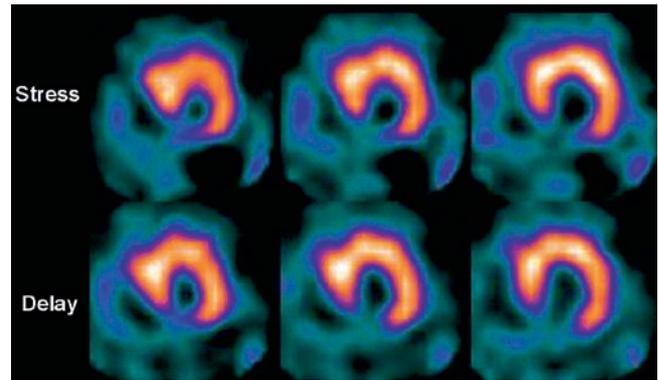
Mid-ventricular short-axis myocardial perfusion SPECT images using ^{201}Tl in a patient with history of inferior wall myocardial infarction. Note the perfusion defect with lack of redistribution on delayed images in inferior wall, indicating absence of myocardial viability
